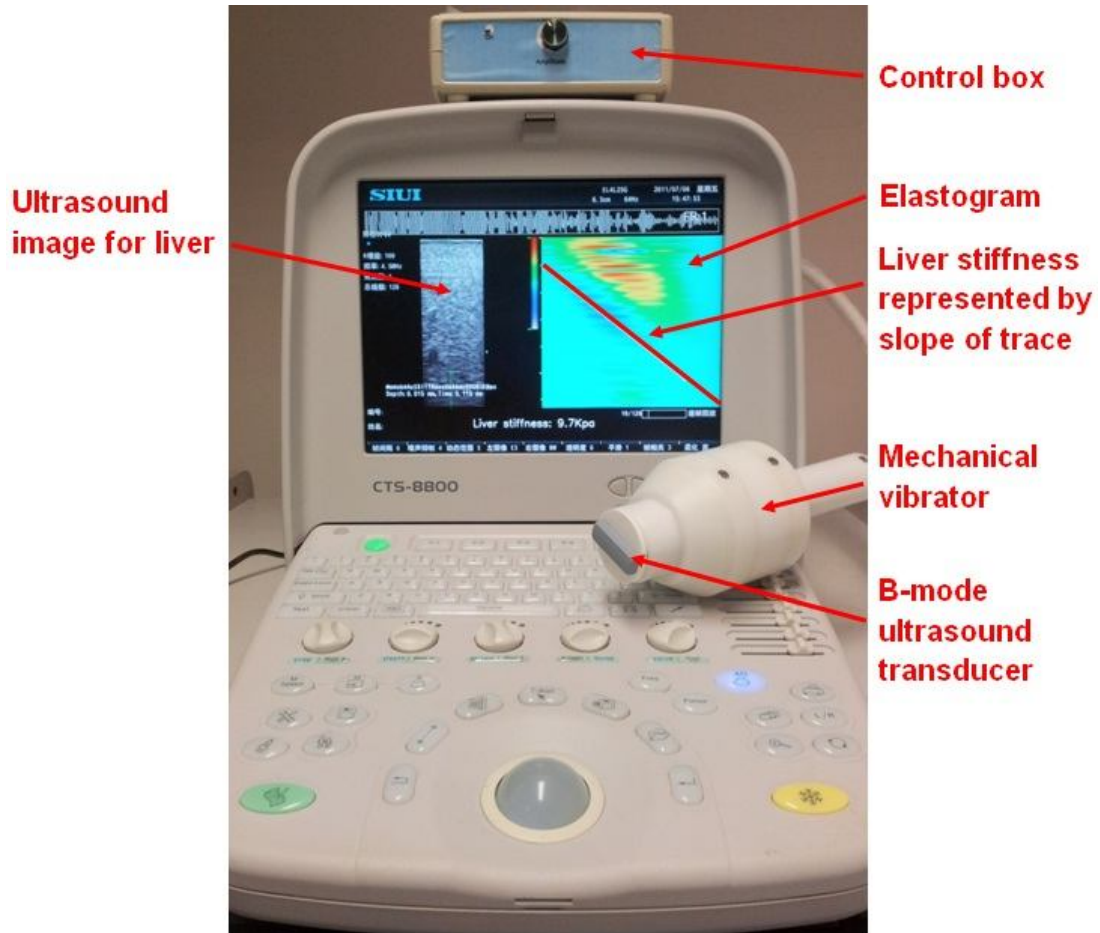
The developed transient elastography system with real-time B-mode ultrasound imaging, Liverscan , with specifically designed probe.
